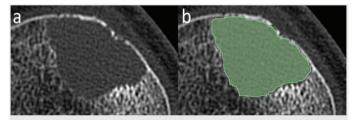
Lesion segmentation. (a) Unenhanced computed tomography image of a 51-year-old man with a giant cell tumor in the proximal tibia. (b) Lesion is segmented using the largest representative axial image slice with a particular focus on the contour
